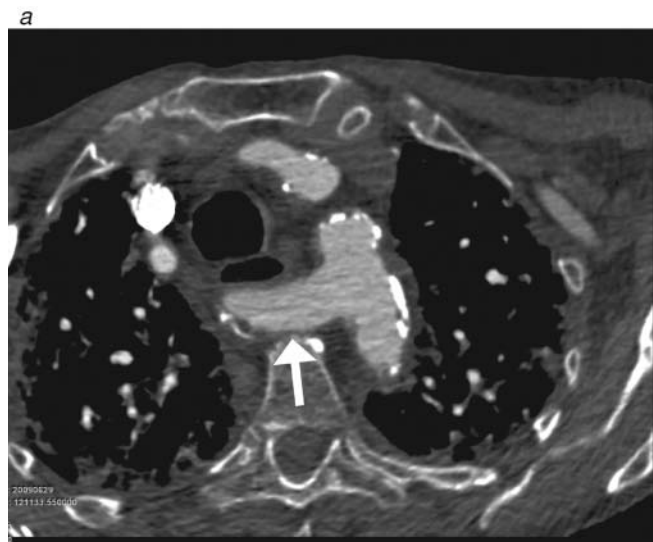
A 63-year-old female presented with dysphagia for solids with no significant weight loss. (a) An axial multidetector computed tomographic angiogram demonstrates an artery arising from the medial aspect of the aortic arch and coursing posterior to the esophagus consistent with an aberrant right subclavian artery (*arrow*). (b) Coronal maximum-intensity projection demonstrates the aberrant right subclavian artery (*arrow*) passing posterior to the esophagus, causing posterior indentation on the esophagus. The dysphagia associated with this anatomic variant is classically known as dysphagia lusoria. This is the most common embryologic abnormality of the aortic arch, occurring in up to 1.8% of the population.
